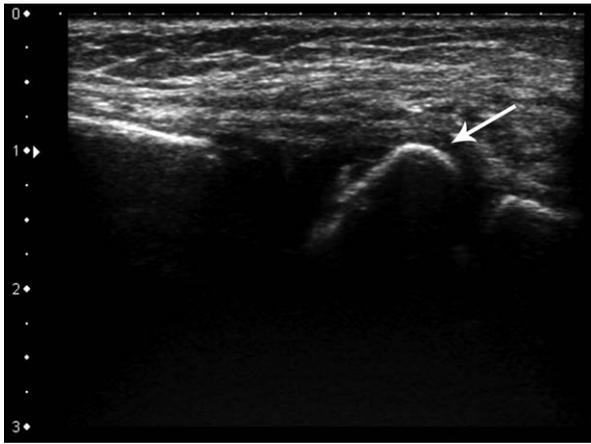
Midline sagittal sonogram of the sternum shows the dislocated and rotated first sternal segment (arrow) with associated swelling of the overlying soft tissues.
